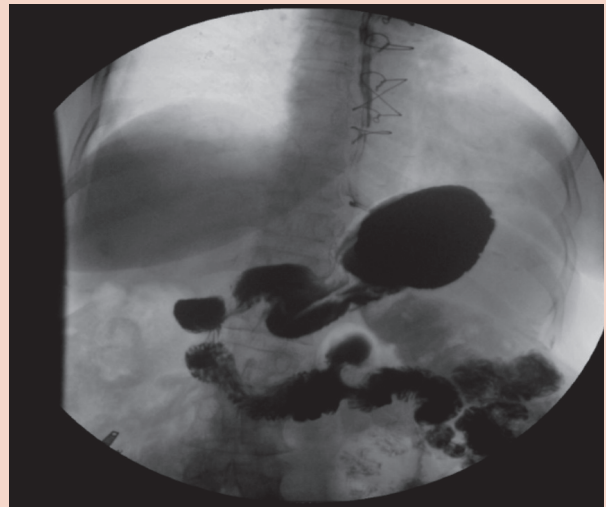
Barium radiography view of the extra-luminal diverticula is seen
